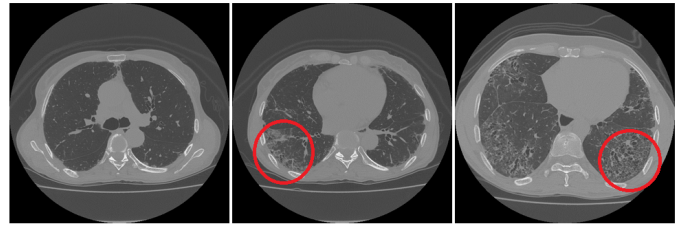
CT images of the chest with healthy tissue (left), with inflammation (center) and with fibrosis (right).
